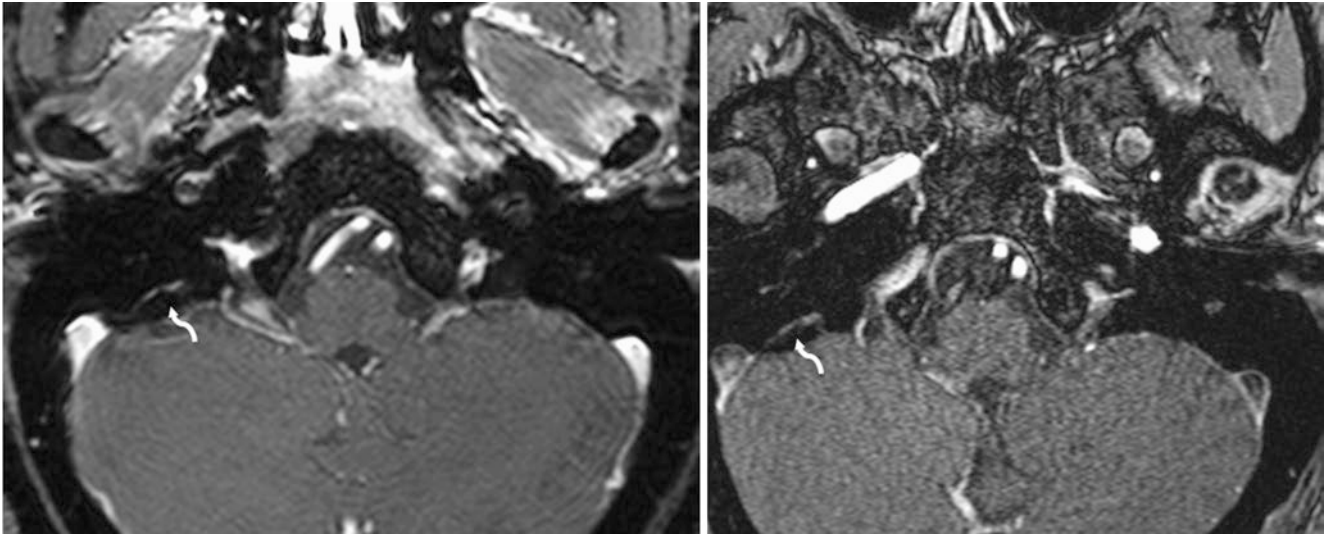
A 55-year-old patient with a negative 3 T MRI for dizziness. On a 0.5-mm thickness postcontrast FS spoiled GET1WI (T1FFE, *left*) and on a postcontrast 3D TOF MRA source image (also a gradient echo
